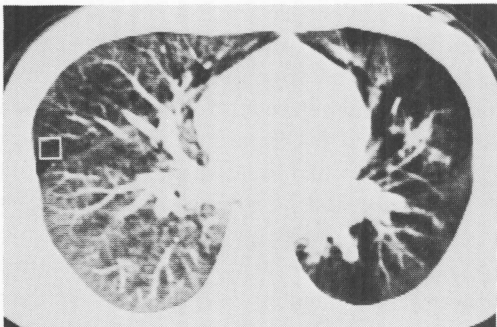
Computed tomography of both lungs
